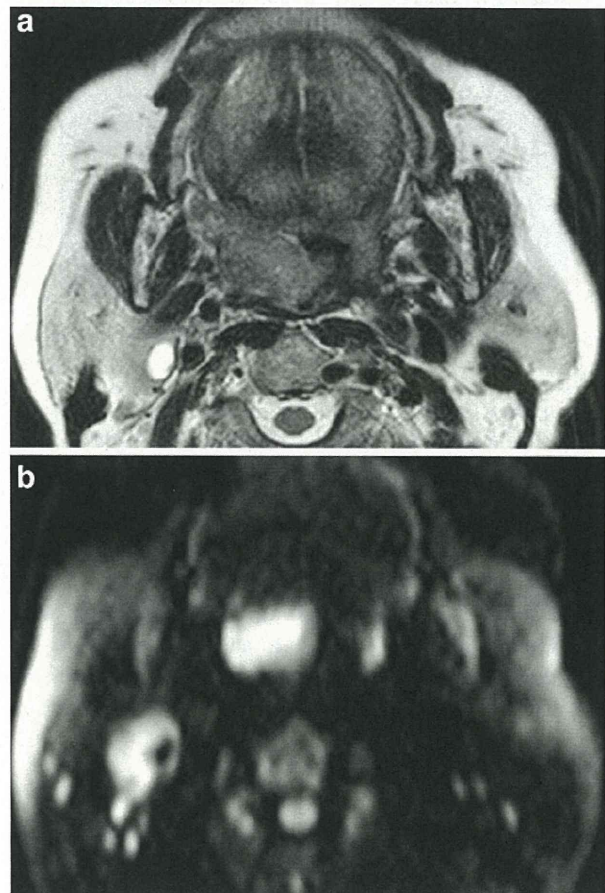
A representative good-prognosis woman in her 70s (disease-free survival with 36.8 months follow-up) with oropharyngeal cancer (T2N2M0, performance status 0, ADC 0–200 = 2.18×10^{-3} mm²/s, ADC 300–1,000 = 0.57×10^{-3} mm²/s). a T2-weighted transverse image. b DW transverse image (*b* = 1,000 s/mm²)
